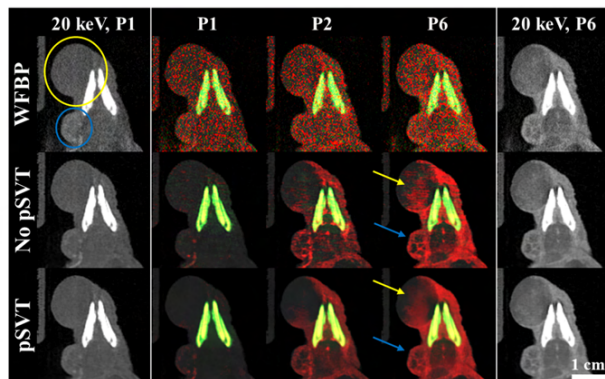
Coronal CT images and material decomposition results are compared between WFBP reconstruction (row 1) and regularized iterative reconstruction excluding (“No pSVT”, row 2) and including (“pSVT”, row 3) pSVT. A yellow circle indicates the location of the primary tumor, while a blue circle indicates the location of a metastatic tumor. Results are shown for perfusion phases 1, 2, and 6 (“P6”). Arrows are referred to in the text. CT window: $[0.0,0.80]$ cm^{-1} . Iodine (red) window: $[1.0,6.0]$ mg/mL . PE (green) window: $[1.0,15.0]$ \times water. CS (gray) window: $[0.0,8.0]$ \times water.
